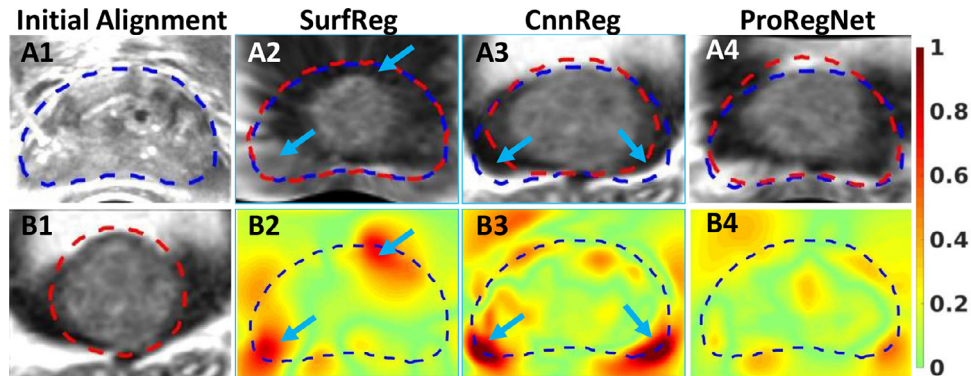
A1: TRUS image. B1: MR image. A2-A4: Deformed MR images after registration by SurfReg, CnnReg and ProRegNet, respectively. B2-B4: JD absolute error for SurfReg, CnnReg and ProRegNet, respectively. Blue contours indicate the TRUS prostate shapes while the red contours indicate MR prostate shapes. Poor registration was observed at regions where JD error was large, as indicated by arrows.
